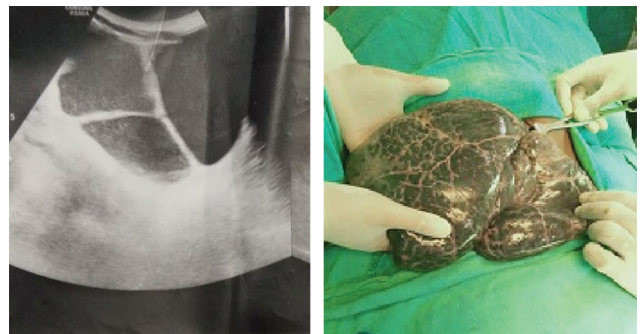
Ultrasonography of a 3-year-old female with abdominal lump showing multiseptated large cyst, omental cyst was found on laparotomy, cystectomy with omentectomy was done.
